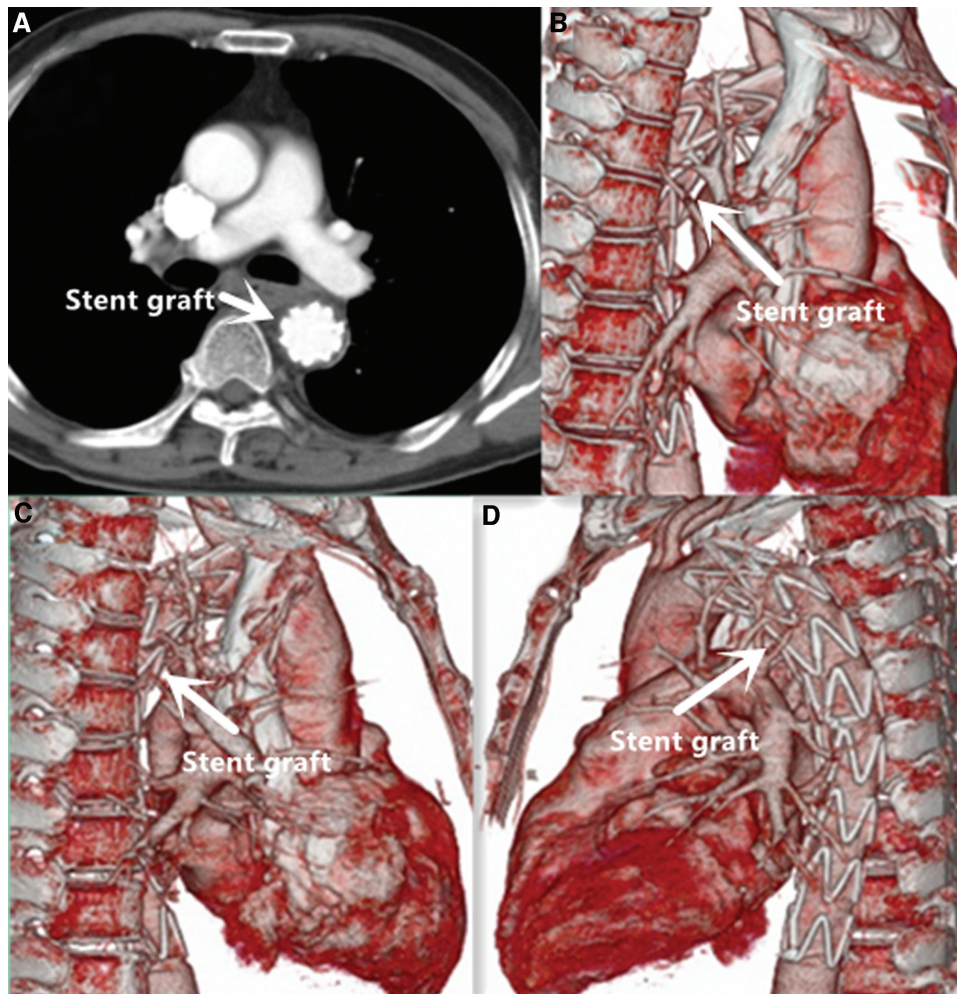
The postsurgical examination. (A) Transverse and (B) three-dimensional volume-rendered computed tomography angiography of predischarge shows complete sealing of the primary entry tear with a thoracic aortic stent. No contrast extravasation from the aortic arch into the mediastinum and the esophagus. (C, D) Three-dimensional volume-rendered computed tomography angiography after 3 months shows a well-positioned thoracic aortic stent. No contrast extravasations into the aneurysmal sac.
